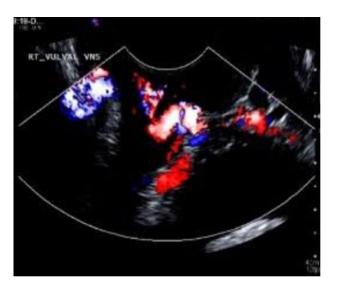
Trans-labial ultrasound imaging revealed a blood flow along the vaginal area, confirming the presence of a vaginal varicosity.
